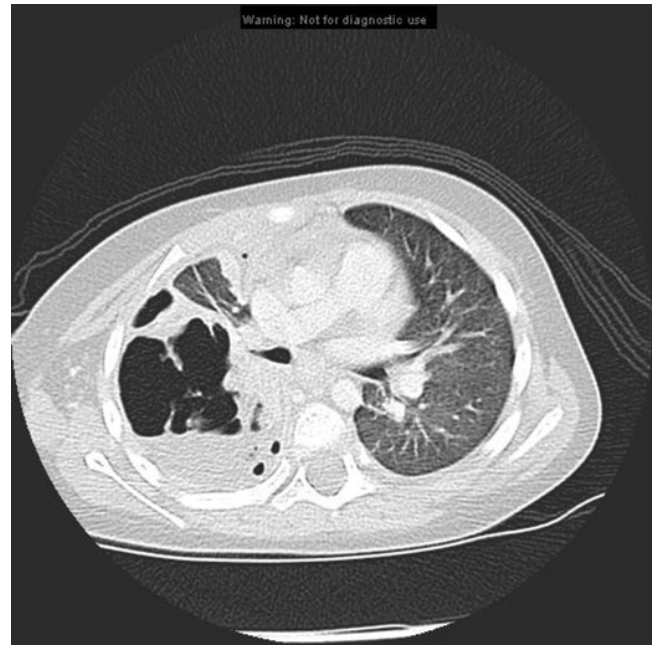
Chest CT of a 2-year-old patient with empyema, transverse view.
